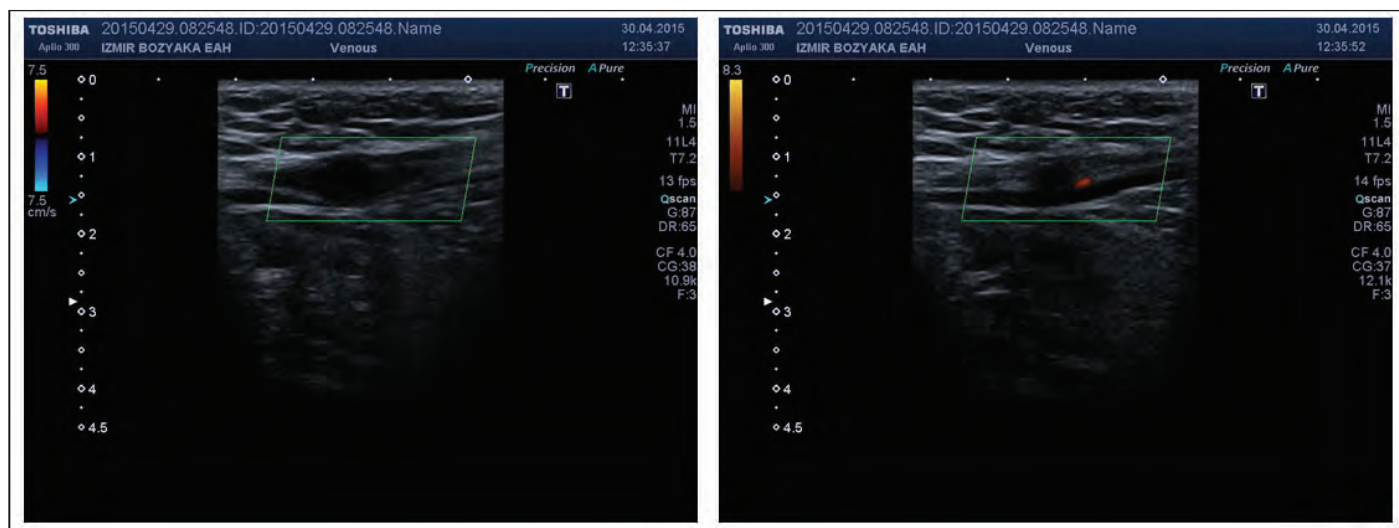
On colour Doppler ultrasound and power Doppler ultrasound, no filling with the colour was seen in the lumen of this vein within the right spermatic cord. On power Doppler ultrasound, filling was seen within the neighbouring arterial structure, but not within the vein.
